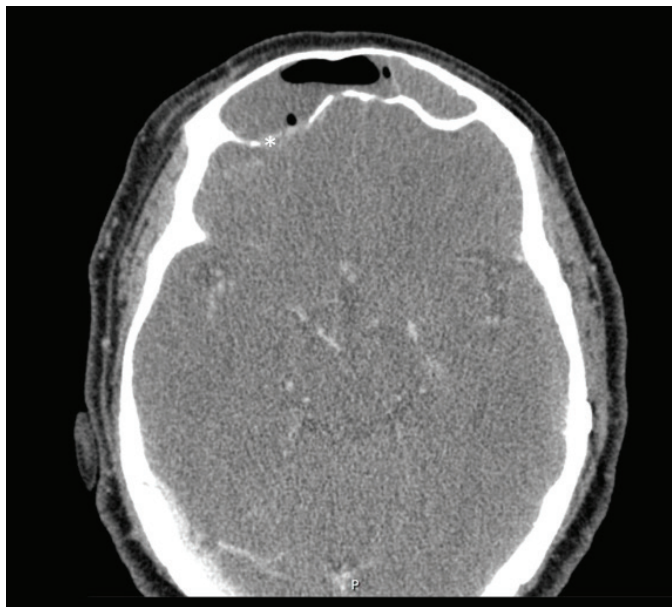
CT-scan at the emergency department (before any therapeutic intervention) a soft tissue opacification of frontal sinus and erosion of the posterior wall of the frontal sinus with associated extradural empyema (*)
